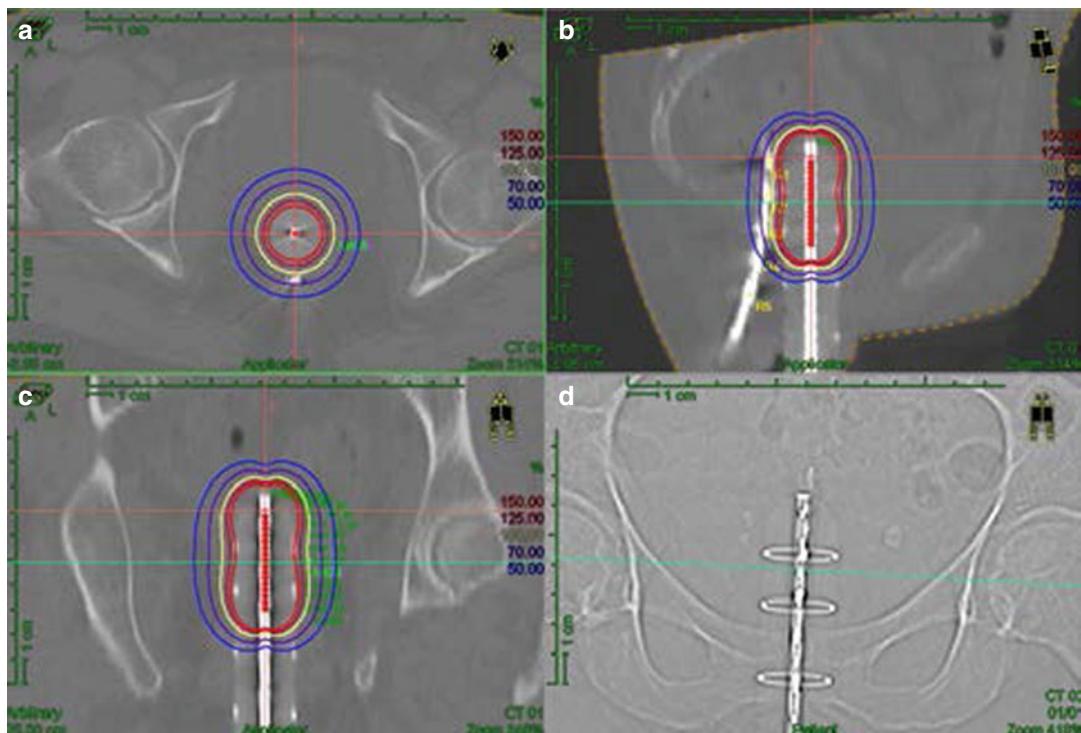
Planning CT in three dimensions (a–c) and an AP radiography (d) for brachytherapy of a cervical cancer with a regular positioned intravaginal applicator and narrowly confined dose distribution
